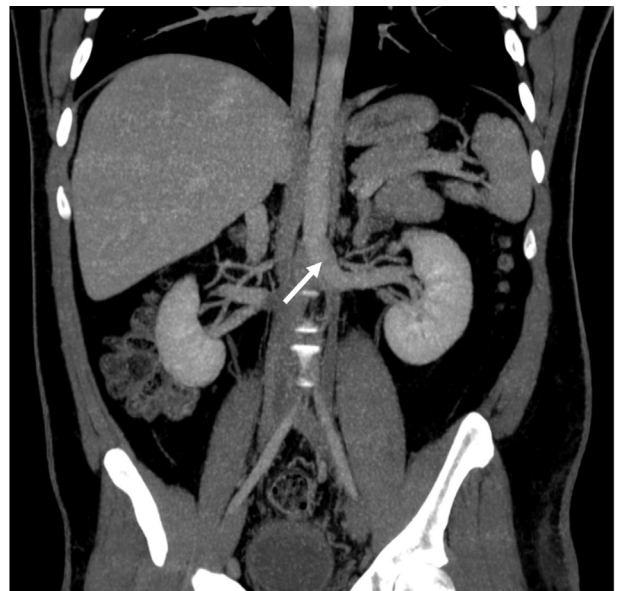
Computed tomography angiography, coronal reconstruction shows the drainage of the left renal vein (white arrowhead) into the azygous system.
